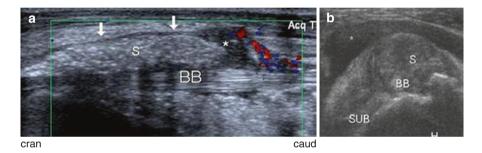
Glenohumeral synovitis. (a) (Longitudinal view): recess of the joint capsule (*down arrow*), tendon of the long head of the biceps brachii (*BB*), thickened synovial sheath (*S*), fluid (*asterisk*) and joint capsule hyperaemia according to colour Doppler US. (b) (Transverse view): tendon of the long head of the biceps brachii (*BB*), thickened synovial sheath (*S*), subscapularis (*SUB*), fluid (*asterisk*); modified according to ref. [13]
